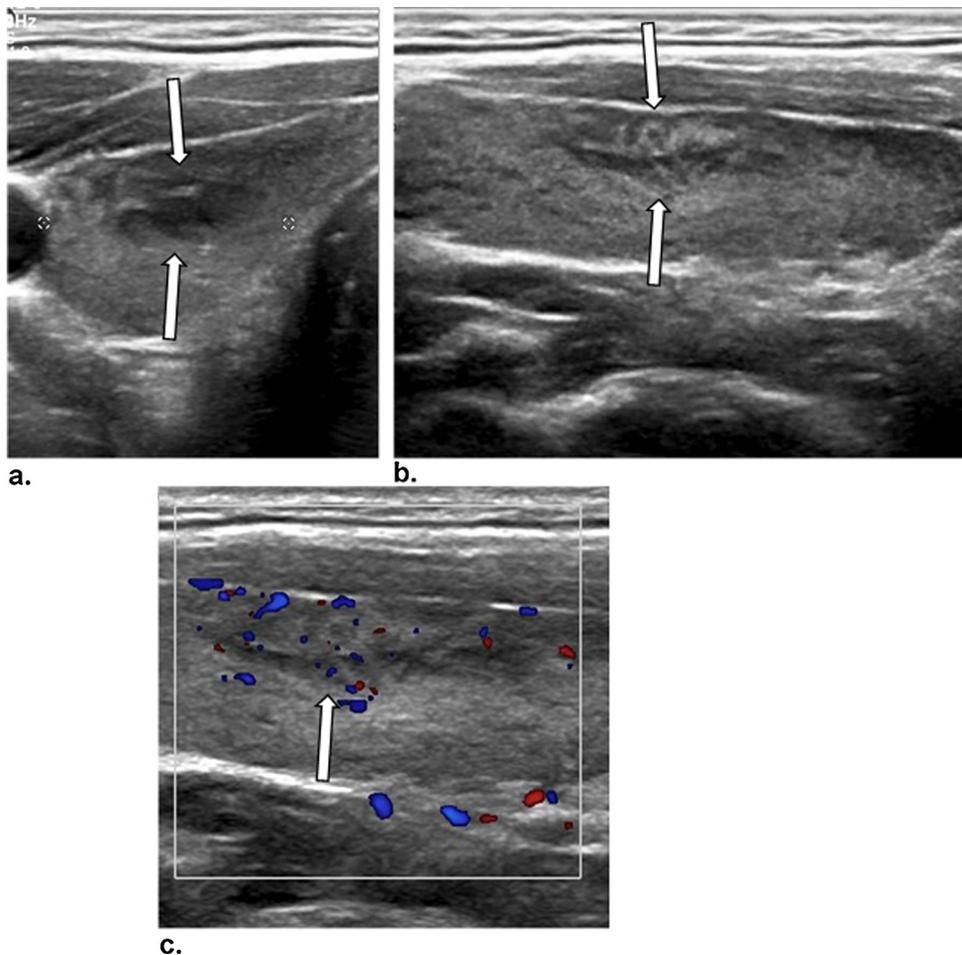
A 29-year-old woman with a clinically suspected thyroid nodule. (a) Transverse and (b) longitudinal gray-scale ultrasound show a nodule at right thyroid lobe (arrows). The nodule is solid, hypoechoic, wider-than-tall, and has an ill-defined margin. (c) A longitudinal color Doppler ultrasonography (not part of TI-RADS) shows mild intranodular vascularity (arrows). The nodule was categorized as TR4. Cytology shows Hashimoto nodules on a background of Hashimoto thyroiditis.
